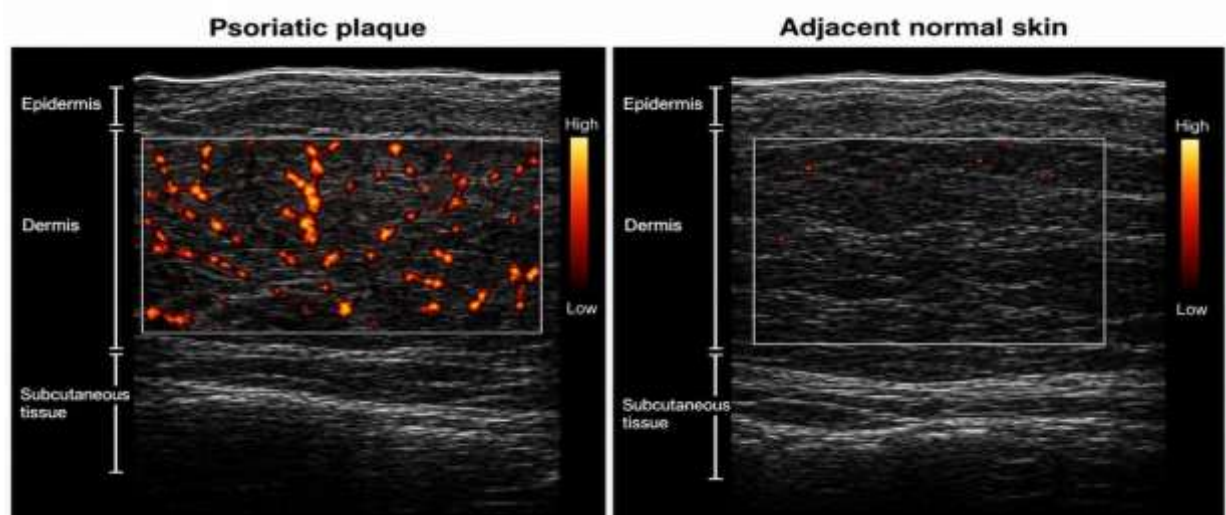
Power Doppler ultrasound demonstrating prominent dermal microvascular signals within a psoriatic plaque, with minimal vascularity in adjacent clinically normal skin.
